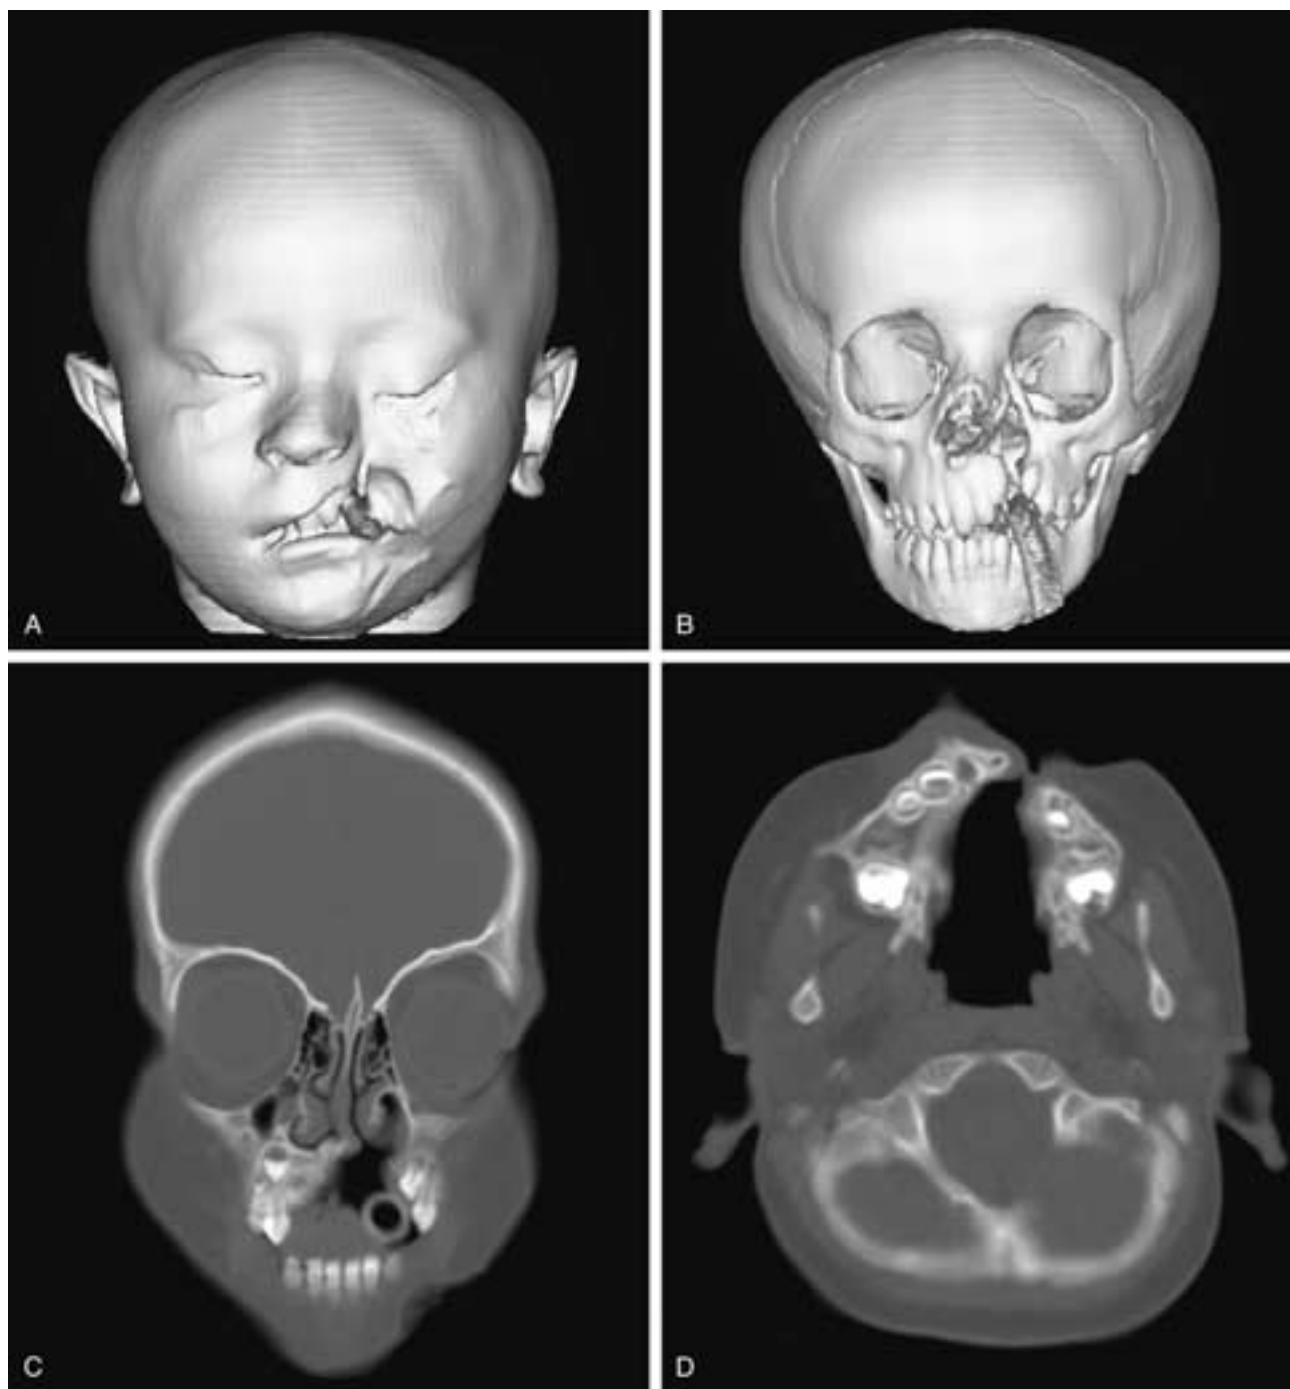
Unilateral cleft lip and palate in a 2-year-old boy. A, Three-dimensional CT of the skin surface. B, Three-dimensional CT of bone surface. C, Coronal CT. D, Axial CT. The unilateral cleft extends through the lip, the alveolar ridge, and the palate on the left. In this patient, the soft-tissue cleft lies lateral to the deformed ala nasi and extends toward the lacrimal sac fossa.
